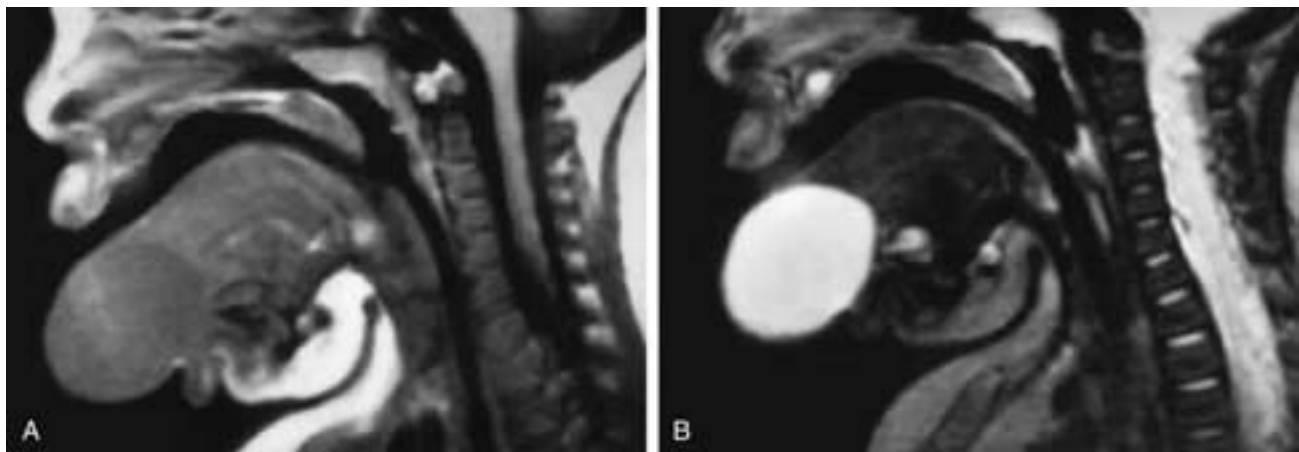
Sagittal T1-weighted (A) and T2-weighted (B) MR images show a large cyst in the anterior tongue of this child. This was a retention cyst.
